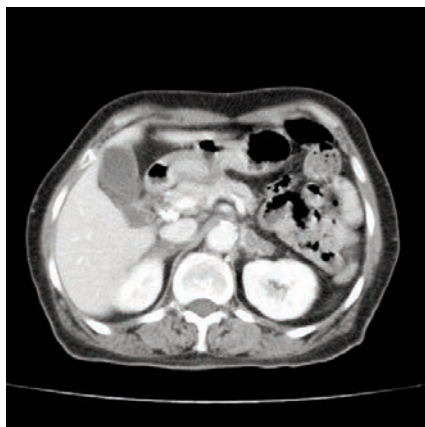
Contrast-enhanced CT scan shows mass-like enlargement and rim enhancement and focal cystic lesion of bilateral adrenal glands on axial images.
